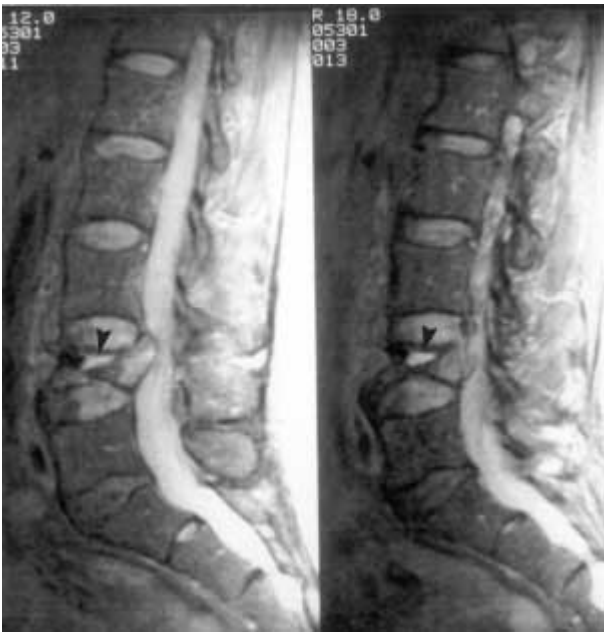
Sagittal T2- weighted MRI showing high signal changes in the L4 vertebral body with retropulsed bone and resulting canal compromise. In addition a linear hyperintense signal was seen with surrounding hypointensity.(see arrow).
